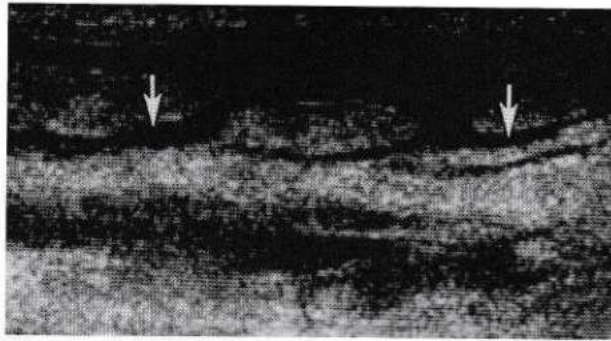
Sonographic image of the calf showing cellulitis
